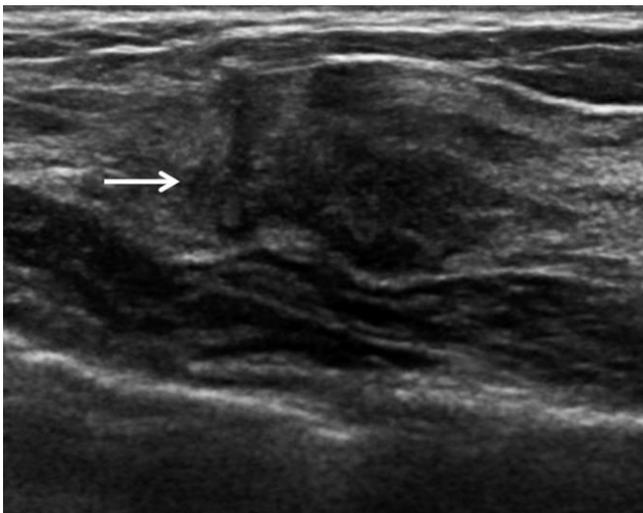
Mammograms from this 46-year-old woman appear normal with heterogeneously dense tissue. Four months later, the woman noted a right breast lump. On ultrasound directed to the lump, an irregular mass (arrow) was identified highly suggestive of cancer. Ultrasound-guided core needle biopsy showed aggressive invasive ductal cancer which was not seen even in retrospect on the mammogram. (Courtesy Dr. Wendie Berg)
